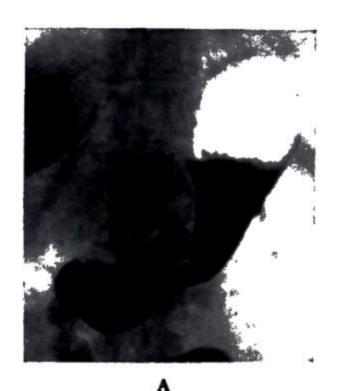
Typical radiographic appearances in carcinoma of the stomach, (A) of the body of the stomach, (B) of the pyloric antrum. (Professor Carl Krebs, Aarhus, Denmark.)
